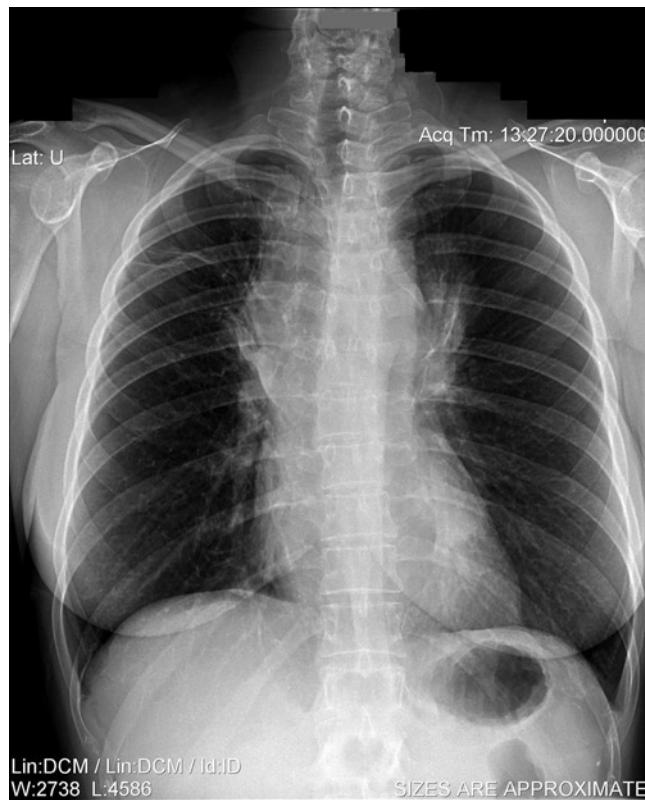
Chest X-ray of a middle-aged woman with a recurrent anterior mediastinal mass and history of treated Hodgkin's lymphoma presenting for biopsy of the mass under GA. Recent percutaneous CT-guided biopsies were nondiagnostic. She was asymptomatic.
